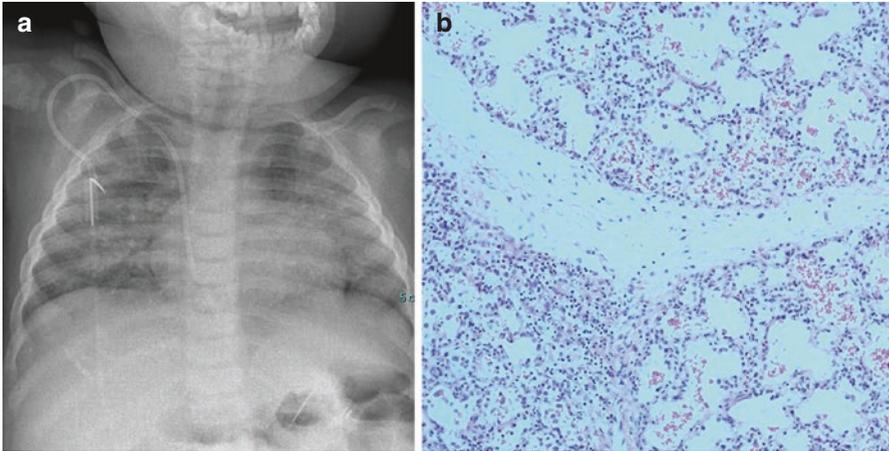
Chest radiograph (a) and lung biopsy (b) from an infant with Omenn syndrome showing interstitial pneumonitis due to autologous T-lymphocyte infiltration – no microorganisms were detected
